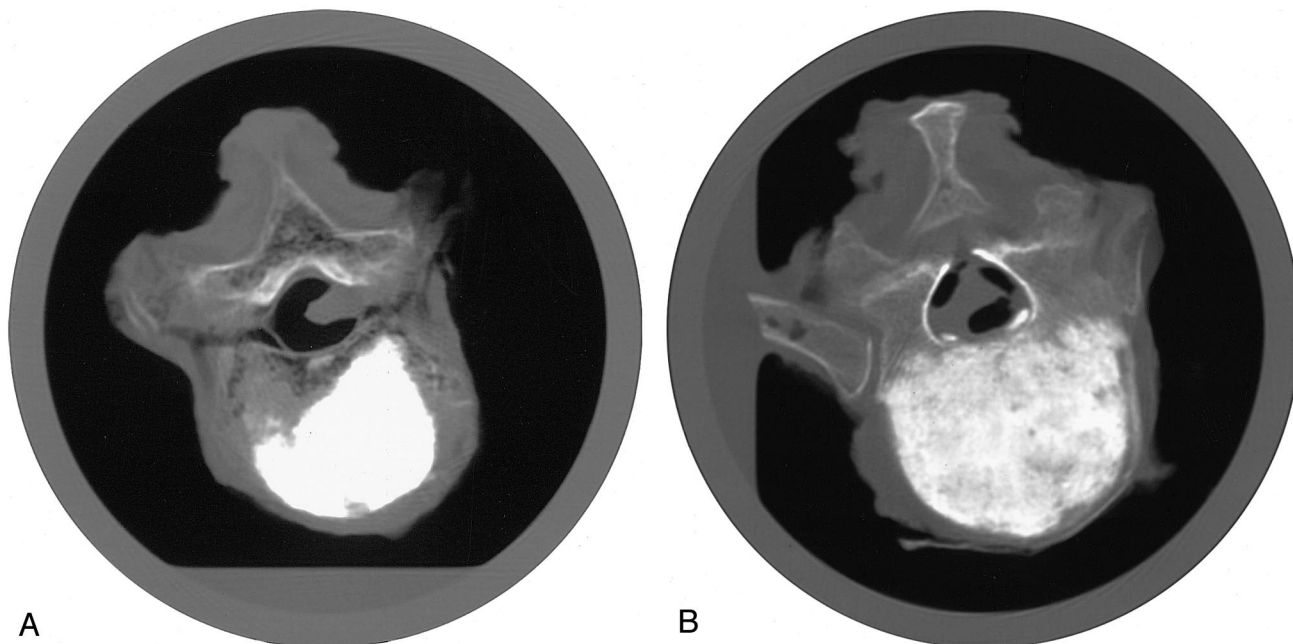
Computed tomography images of the augmented vertebrae: A, Central slice of a vertebra augmented using direct injection and B, A central slice of a vertebra augmented using reduction/injection.
